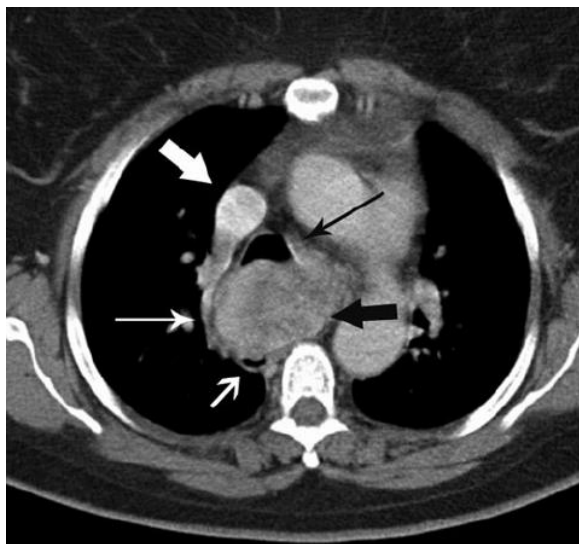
CT scan shows a massive goiter and tracheal compression on the right (arrow).
